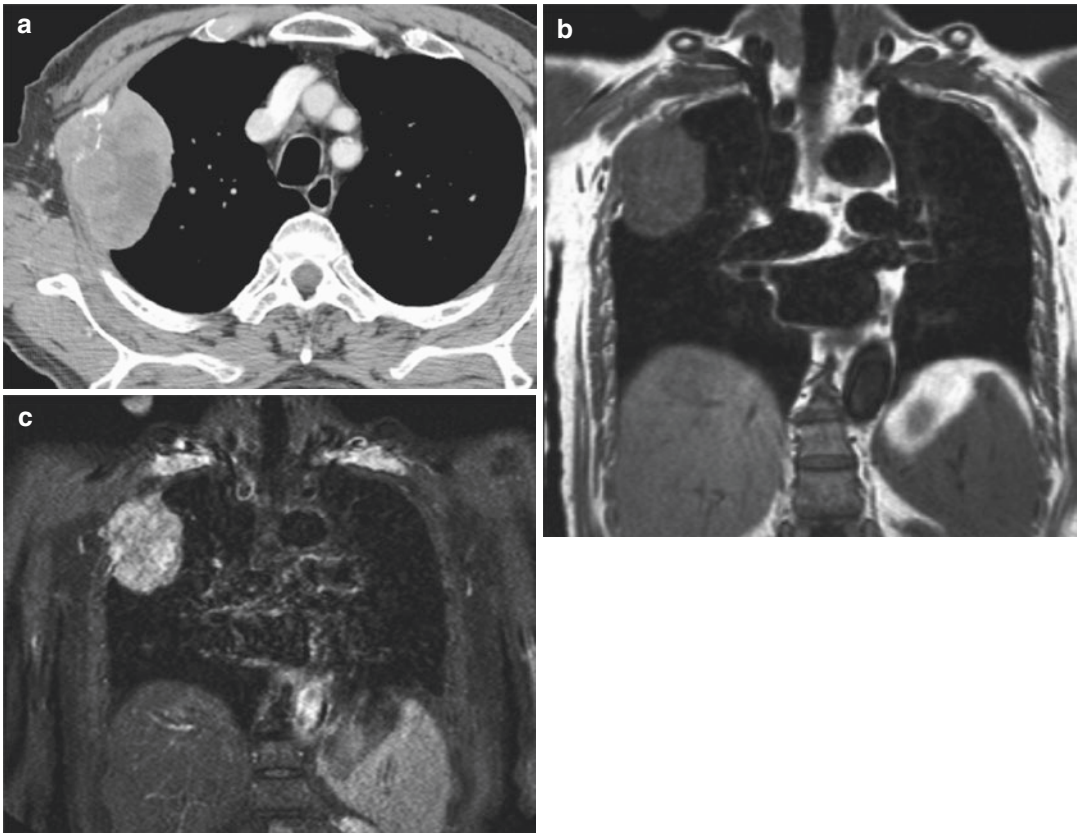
A 71-year-old male with adenocarcinoma in the right upper lobe. Contrast-enhanced thin-section CT (a) and conventional T1-weighted SE (b) images suggest
